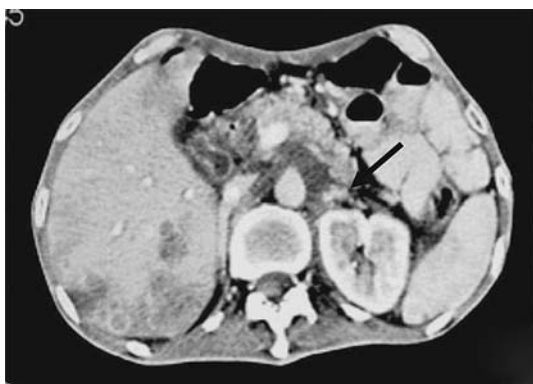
Posttreatment CT checkup shows that the enlarged lymph node is evidently necrotic and shrunken (*arrow*).
